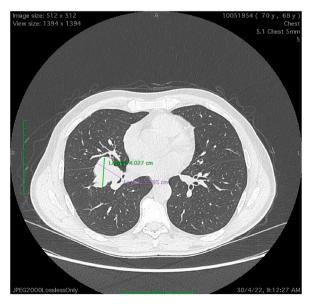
CT scan depicting right lower lobe mass measured spacing the right major fissure.
